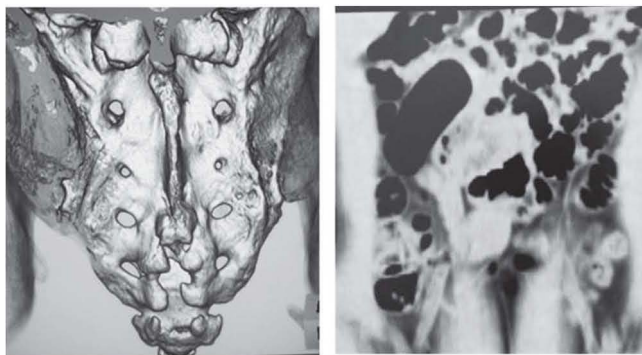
CT image of spina bifida (left) with a large amount of intestinal gas (right). In this case, fecal incontinence was improved with a low-FODMAP diet. His fecal incontinence had been misdiagnosed and was attributed to mental retardation as his school teachers believed that he was doing this on purpose. A large amount of gas was found in his abdomen. His incontinence occurred mainly with the excretion of gas. Therefore, a low-FODMAP diet was expected to be effective. When he followed a low-FODMAP diet, his fecal incontinence disappeared, he graduated from high school, and he is now going to university.
